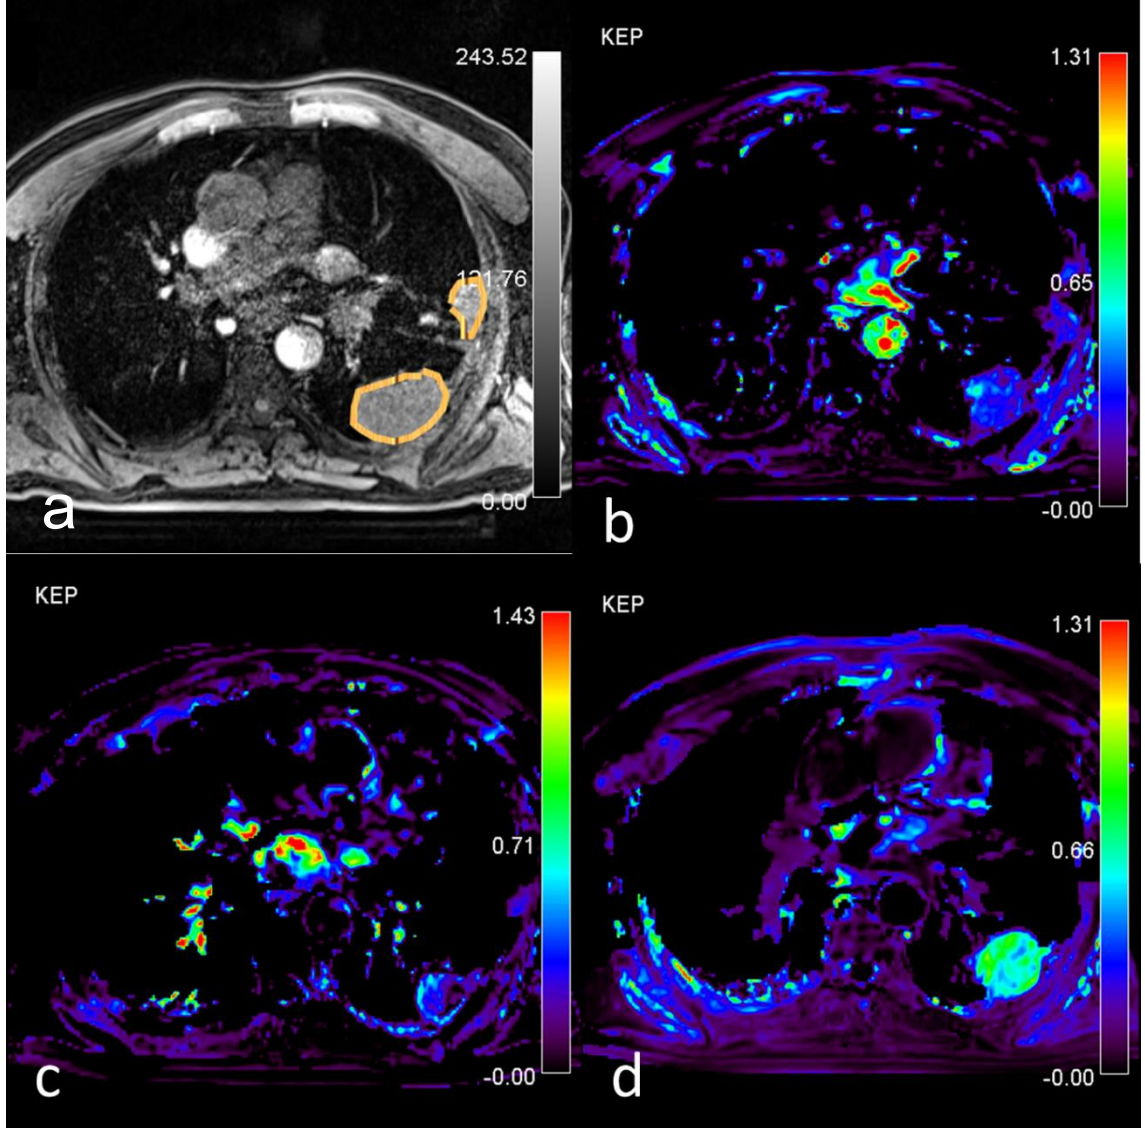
Patient with stable disease. a) Post-contrast T1-weighted turbo-FLASH. Source image shows the region of interest (ROI) drawn around the tumor, AATH-calculated k_{ep} parametric map (1/min) from b) pre-treatment, c) intra-treatment, and d) post-treatment study is shown. Tumor remained almost the same size during the treatment which was accompanied by stable k_{ep} values.
